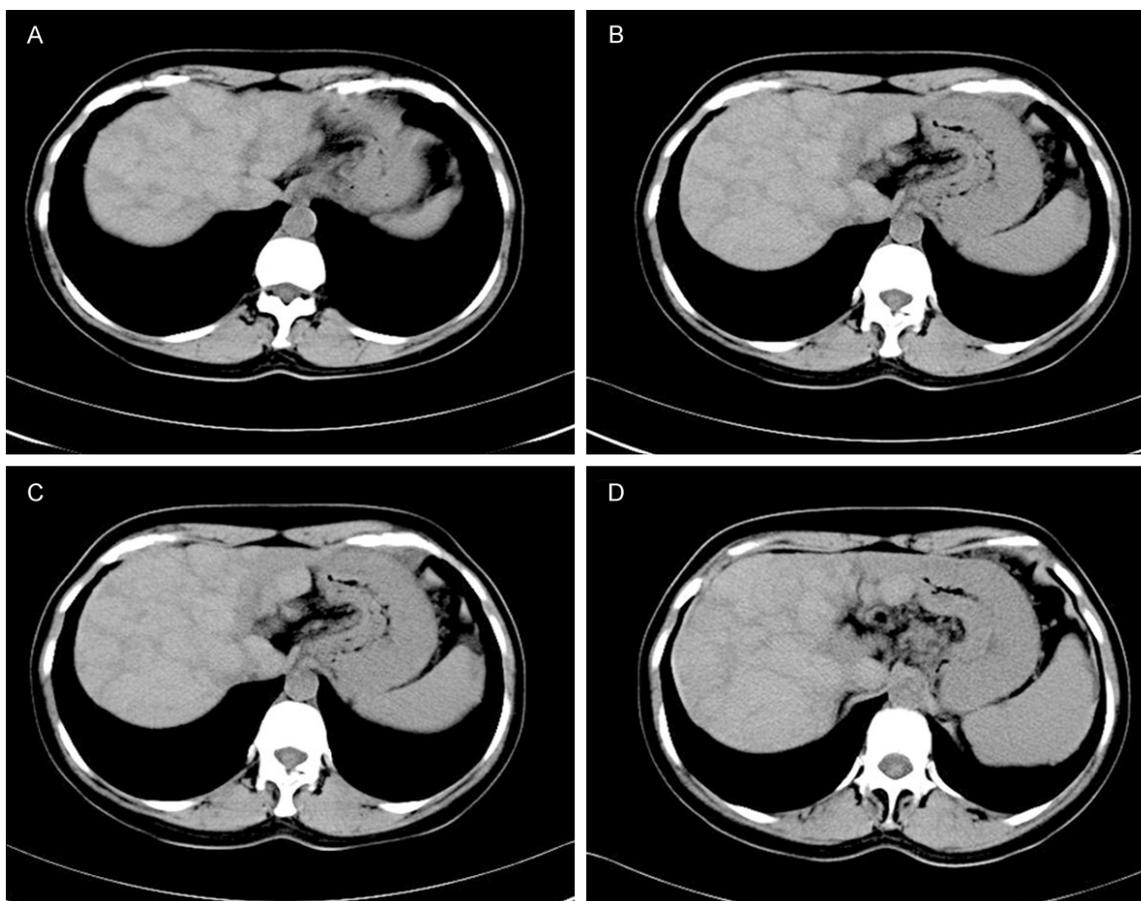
Abdominal CT imaging of the liver. A rough inner structure, central swelling and peripheral atrophy are revealed. Multiple nodules in the liver are apparently demonstrated. In addition splenomegaly is shown.
